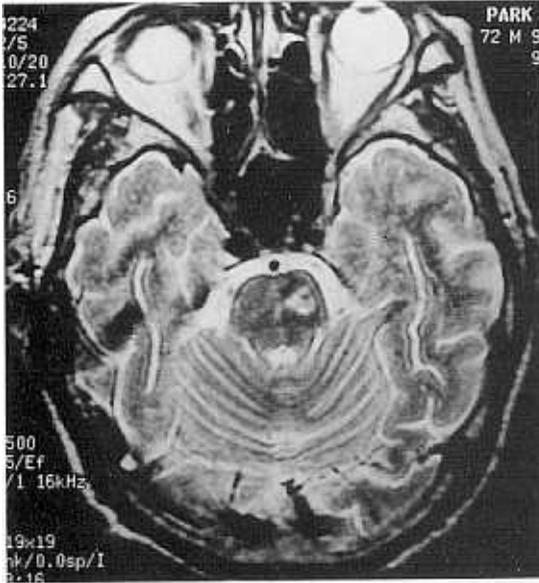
Axial T₂-weighted magnetic resonance imaging of the brain shows a lesion of small high signal intensity in the left midpontine tegmentum, consistent with an infarction.
